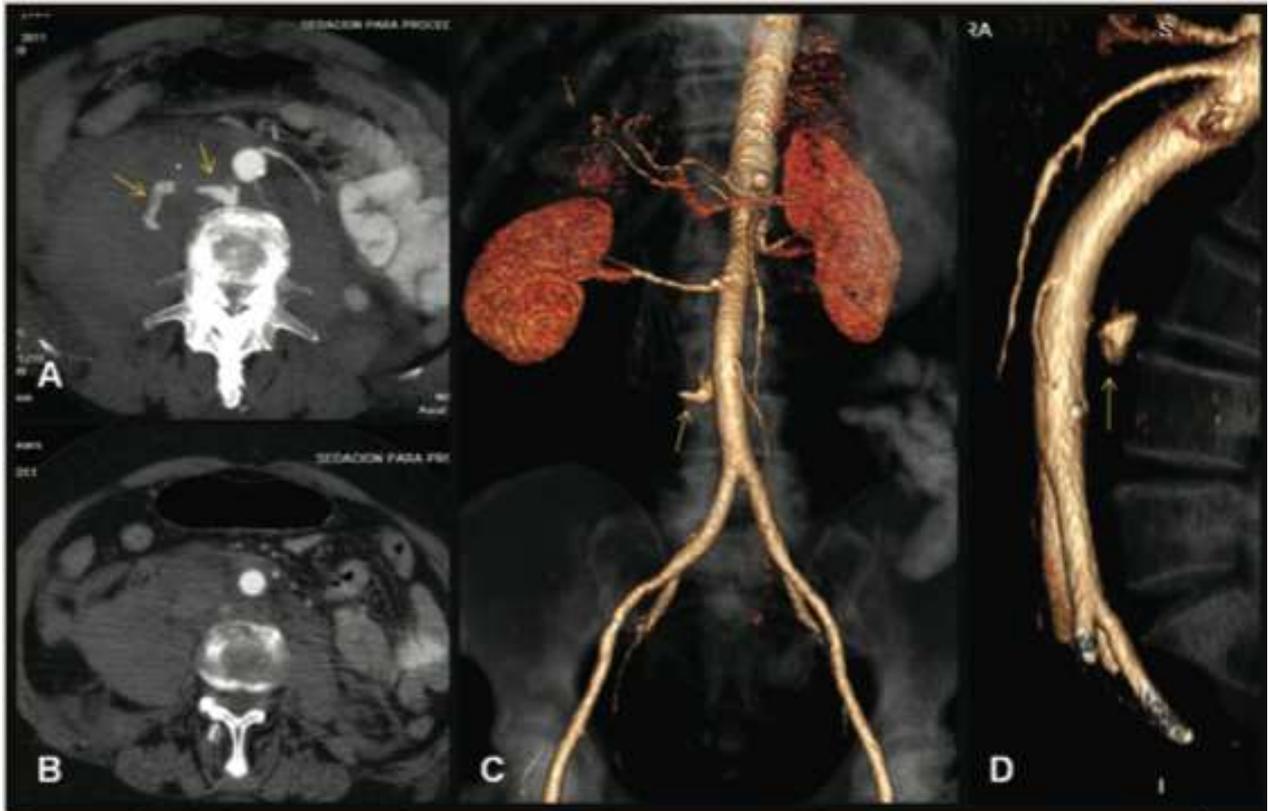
Multislice computed tomography showing active bleeding with extravasation of contrast medium (arrows) from the back of the infrarenal abdominal aorta (A). Multislice computed tomography shows the extent of retroperitoneal hematoma (B). Three-dimensional reconstruction of multislice computed tomography showing extravasation of contrast medium from the back of the aorta (arrows) up to the ostium of the inferior mesenteric artery (C).
